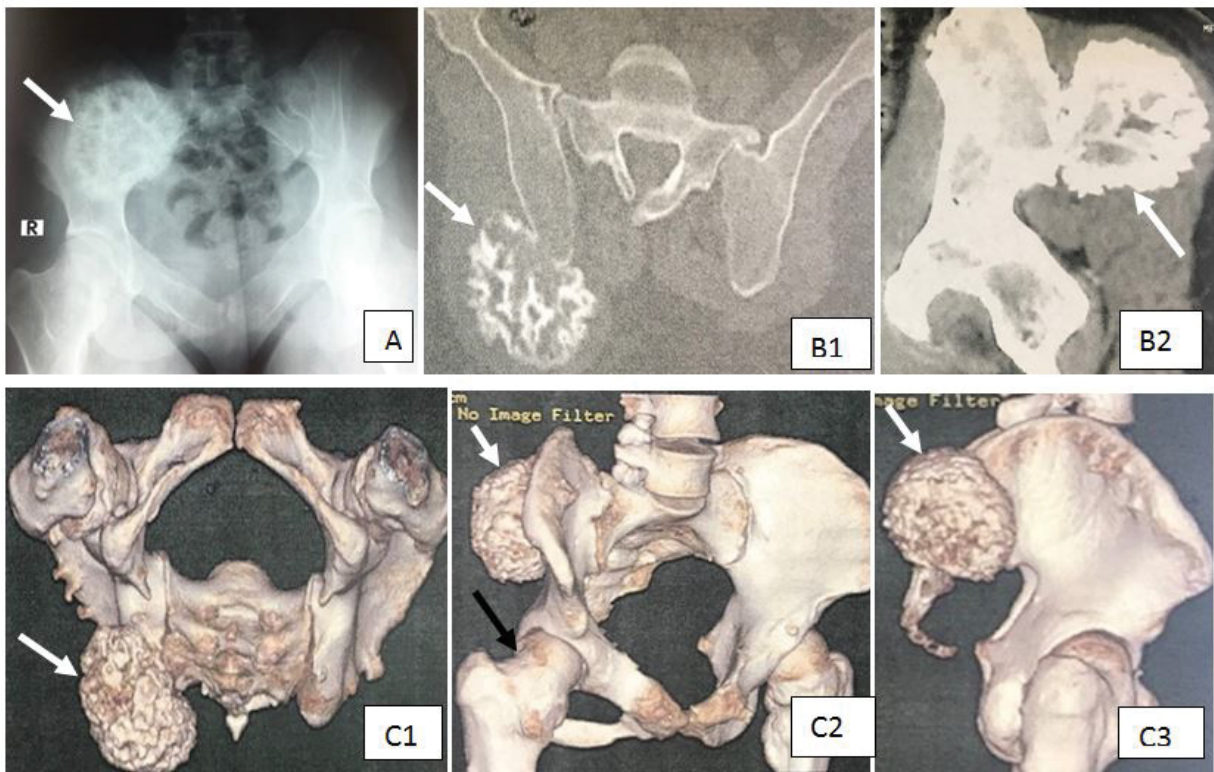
X-ray of the pelvis (A). CT-scan of the pelvis (B)with reconstruction images (C);Highlighting of several bony growths involving the two iliac bones and the pelvis as well as the sacrum, with a wide implantation base and whose cortex continues with that of the supporting bone. In the posterior edge of the right iliac bank, a voluminous bony outgrowth sits with a peripheral cartilaginous component, budding contours and protruding into the ipsilateral gluteal muscles, measuring 64/63 mm and is extended over 65 mm(white arrows).It is associated with other bone formations at the femoral necks which are enlarged(Black arrow).
